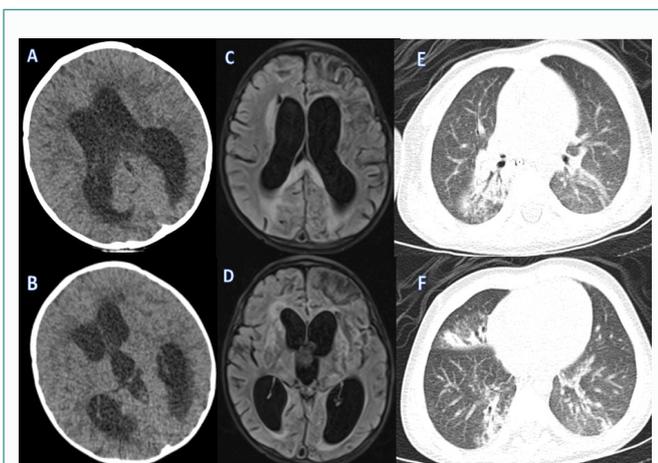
A,B Cranial CT: tetra-ventricular ventriculomegaly C,D Cranial MRI: volume loss in both periventricular deep white matter and at the level of bilateral basal ganglia, also diffuse contrast enhancement in leptomeningeal areas of basal ganglia, left frontal and left temporal sides. E,F Torax CT: the largest of which is 13 mm × 14 mm LAPs in the mediastinum, millimetric nodules on upper lobes of lungs bilaterally, lobular atelectatic areas and ground glass appearances in the lower lobes of lungs.
